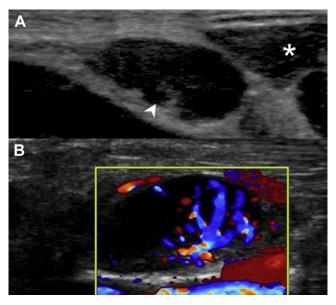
A, Point-of-care ultrasound of the lower neck and internal jugular chain demonstrating multiple enlarged (approximately $2 \text{ cm} \times 1 \text{ cm}$), hypoechoic, elliptic, and elongated lymph nodes; one of them is marked with an arrowhead. B, Color Doppler sonogram of the same reactive lymph node revealing extensive vascularity originating in the hilum. The sternocleidomastoid muscle is marked with an asterisk.
